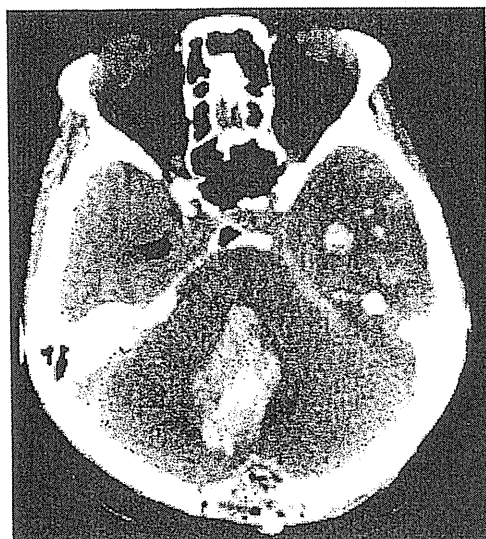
Cerebellar vermis hemorrhage is evident by CT.
